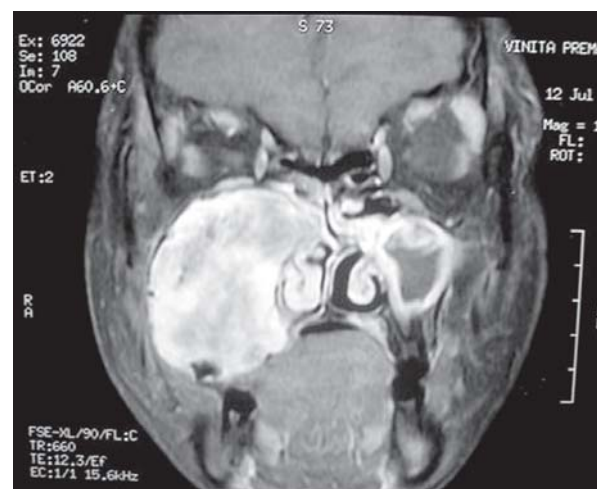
MRI- Scan T2 coronal section showing central fibroma, (Ref. Fig. 18.7R) lesion seen as heterogenous hyperintensity
